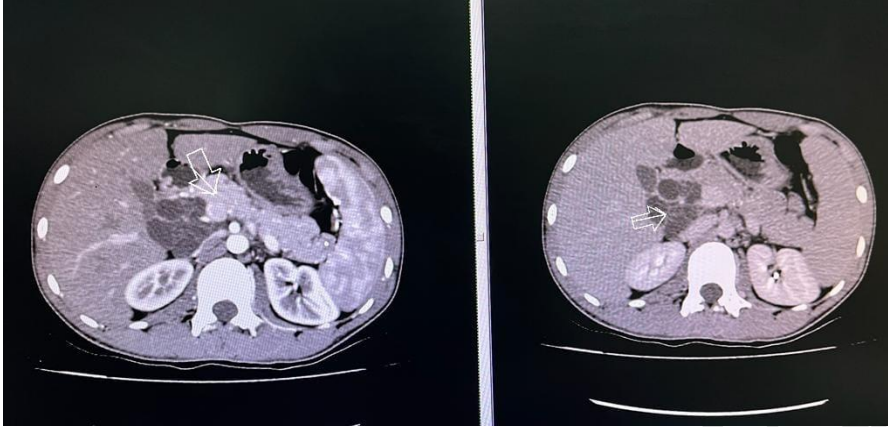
CT scan showing cystic appearance of the pseudo-cyst (arrow) in arterial phase and in delayed phase (arrow).
